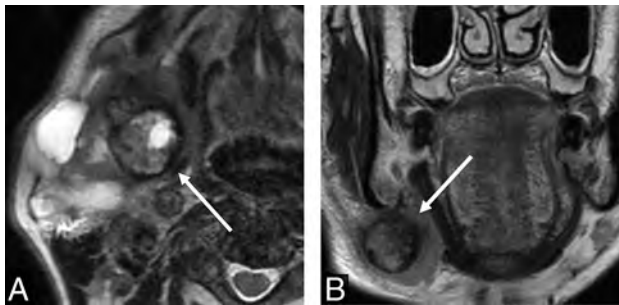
Black ring sign. Invasive CXPA (high-grade mucoepidermoid carcinoma) of the right submandibular gland in a 76-year-old man. MRI shows a nodule with a thick low-intensity rim (A and B, arrows) and an intra-ring component with mixed high- and low-intensity signals on axial and coronal T2WI (A and B). We defined this MRI finding as the black ring sign.
